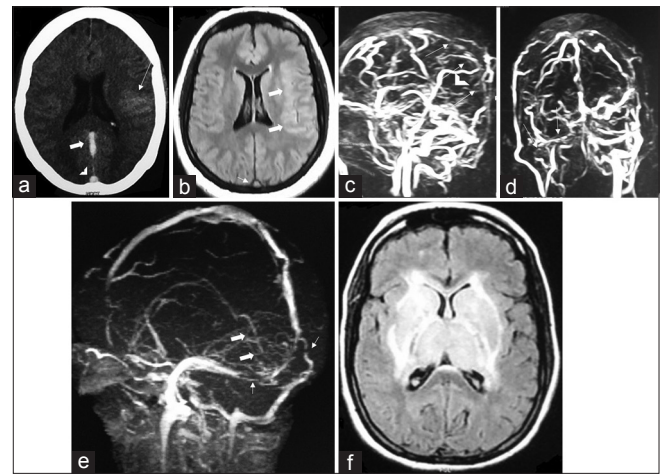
A 34-year-old female with seizure had (a) Hyperdensity of straight sinus (thick arrow) and superior sagittal sinus (arrowhead) and subarachnoid hemorrhage of the left parietal region (long arrow) on noncontrast computed tomography head. (b) Thrombus at superior sagittal sinus (short arrow) and subarachnoid hemorrhage of the left parietal region (thick arrows) on fluid-attenuated inversion recovery. (c) Magnetic resonance venography showed thrombosis of superior sagittal sinus (long arrows), straight sinus (arrowhead) and (d) Left transverse sinus and sigmoid sinus (long arrows). (e) A 23-year-old female (postpartum) with altered sensorium had thrombosis of deep venous system (thick arrows) and bilateral transverse sinus (short arrows) on magnetic resonance venography, and (f) nonhemorrhagic venous infarcts of bilateral thalami and basal ganglia on fluid-attenuated inversion recovery sequence
